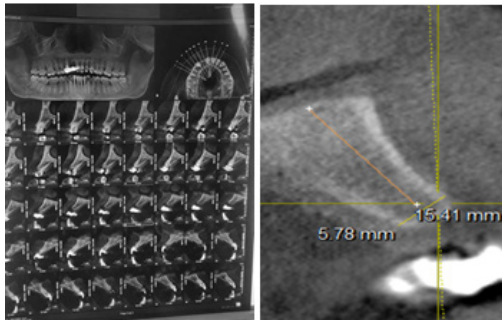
Cone beam + sagittal sections.
